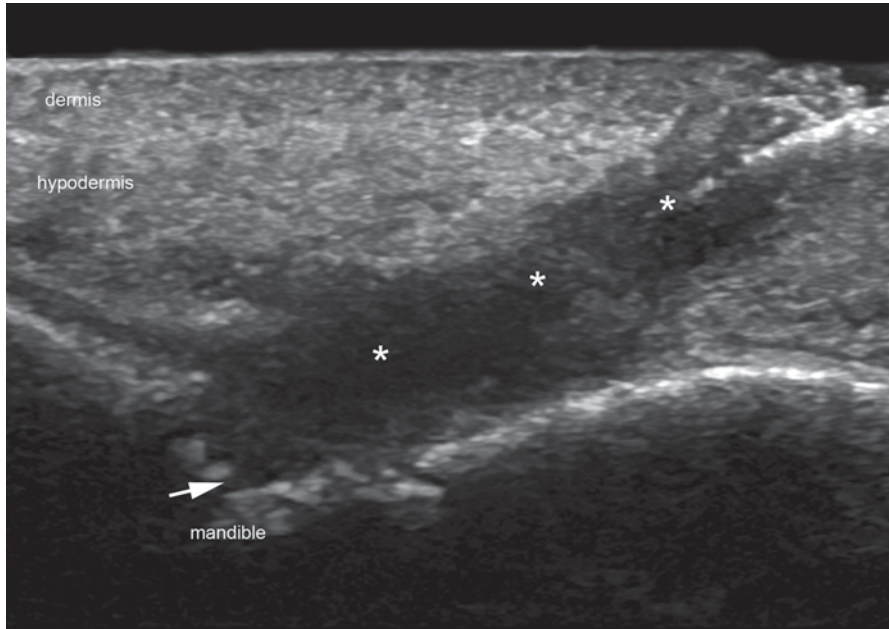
Odontogenic fistula. Ultrasound (*gray scale, longitudinal view, chin region*) demonstrates hypoechoic fistulous tract (*) that connects the subepidermal region with the bony margin of the mandible. Notice the erosion of the bone (*arrow*) at the end of the fistula
